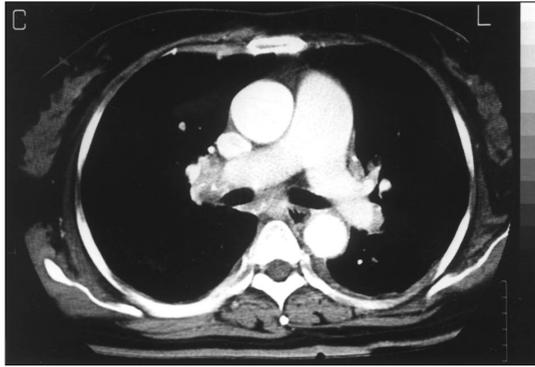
Chest CT scan showed filling defects on both main pulmonary arteries.
